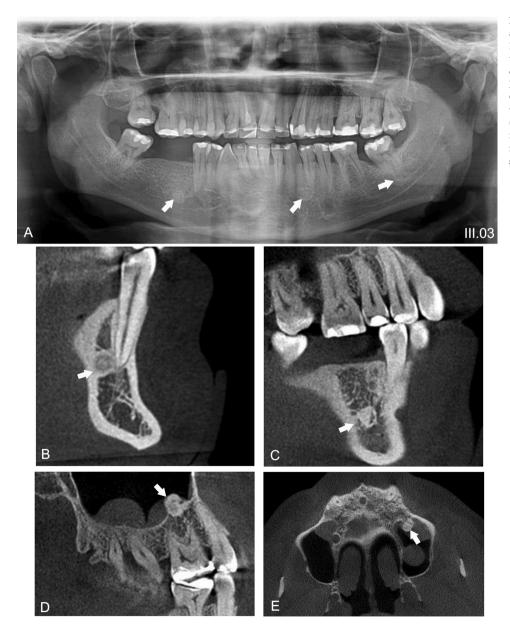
Dento-osseous anomalies in a FAP affected patient (white arrows). (A) Patient III.03- Dense bone island area in the region of the absent lower right first molar, and presence of hazy sclerosis associated with the roots of the lower left first premolar and third molar. (B) CBCT sagittal showing hazy sclerosis associated with the roots of the lower left first premolar. (C) CBCT sagittal demonstrating dense bone island area in the region of the absent lower right first molar. (D, E) CBCT sagittal and axial showing the osteoma in the left maxillary sinus.
